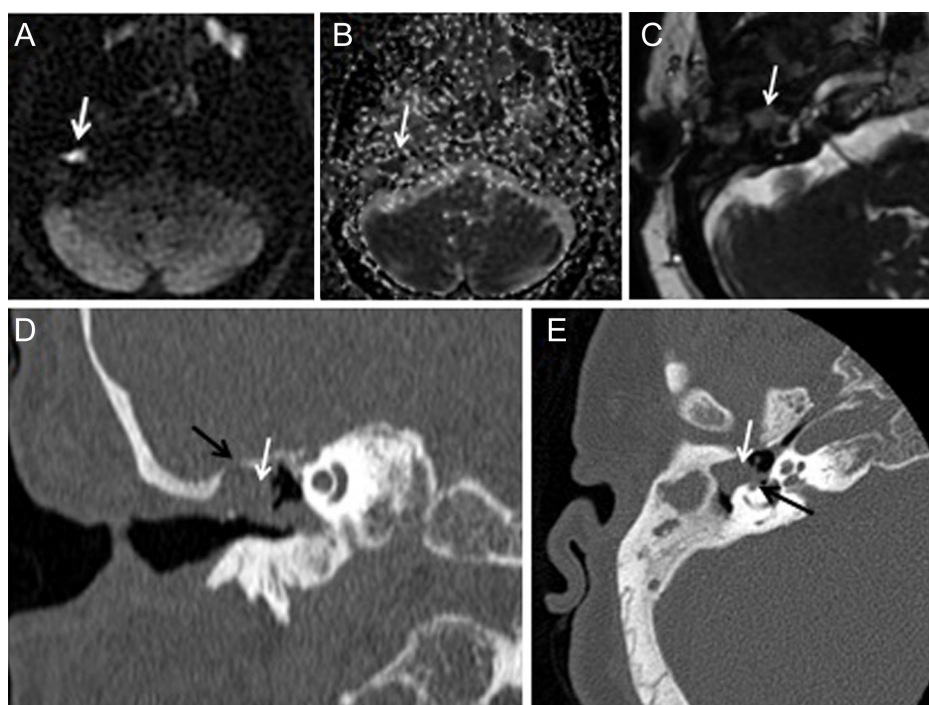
Right-sided millimetric nodular diffusion restriction non-echo-planar diffusion-weighted image (A) and apparent diffusion coefficient map (B). (C) On thin-sliced T2-weighted image, the nodular lesion in tympanic cavity, fistulized to inner ear. (D) On coronal CT image, the opacity filling the tympanic cavity (white arrow) which is not all cholesteatoma when confirmed by MRI and bony destruction in tegmen tympani (black arrow). (E) Cholesteatoma located in the medial epitympanic recess (white arrow) fistulized into the semicircular canal (black arrow) in the axial CT image corresponding to the thin-section T2-weighted MR image. CT, computed tomography; MRI, magnetic resonance imaging.
